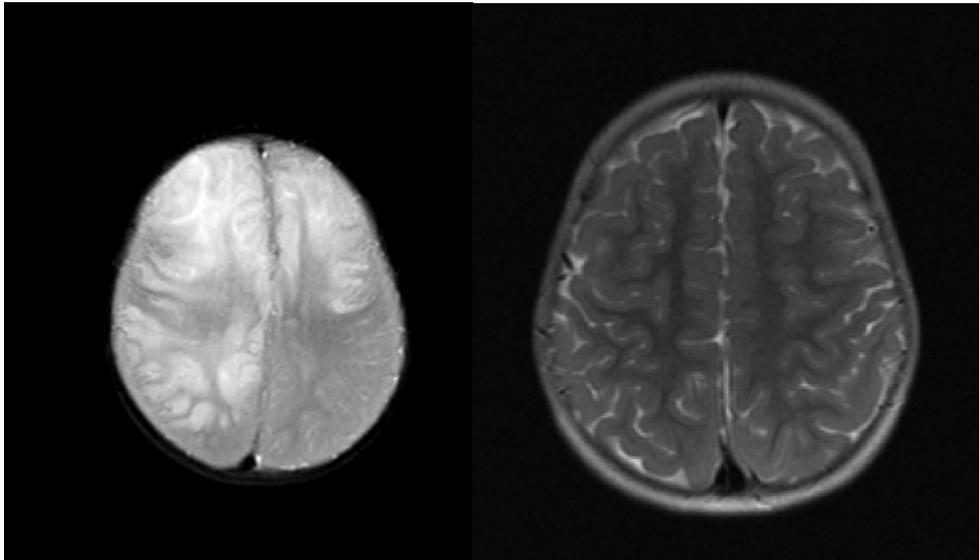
Data on MRI of brain at moment of presentation (13 months)
